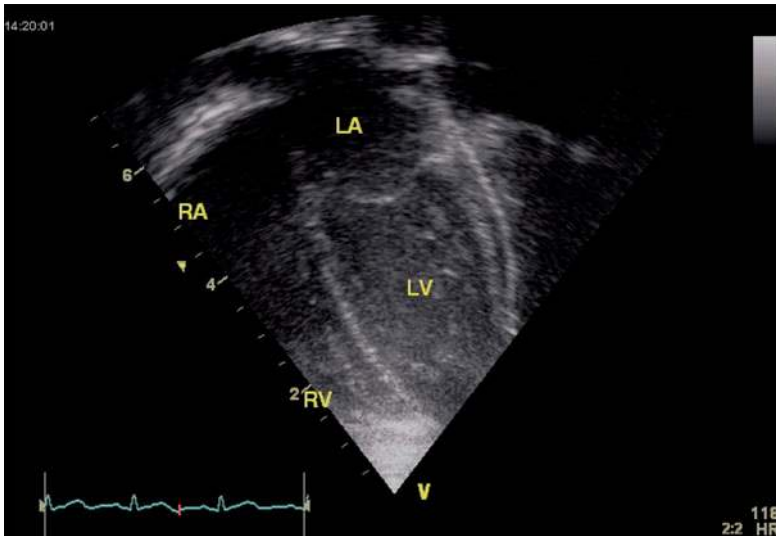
Apical four-chamber view in a normal patient
